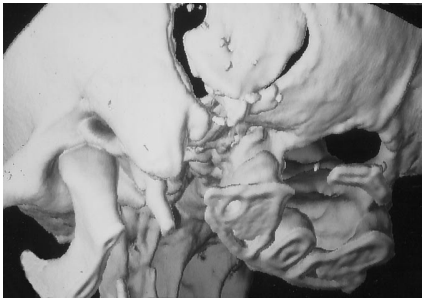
Three-dimensional reconstruction of a computed tomographic scan of the bony cranium demonstrating the extent of the craniotomy.
